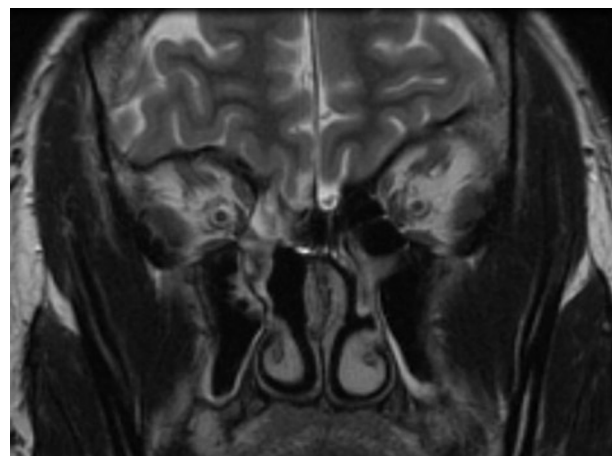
Postoperative MRI coronal view with arrow demonstrating leptomenigeal enhancement but no encephalocele or other pathology. MRI indicates magnetic resonance imaging.
